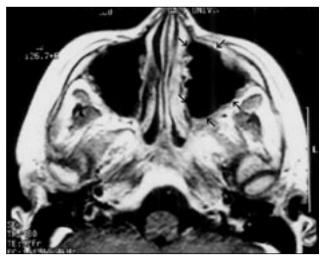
MRI taken after completion of treatment shows complete resolution of the lesion
